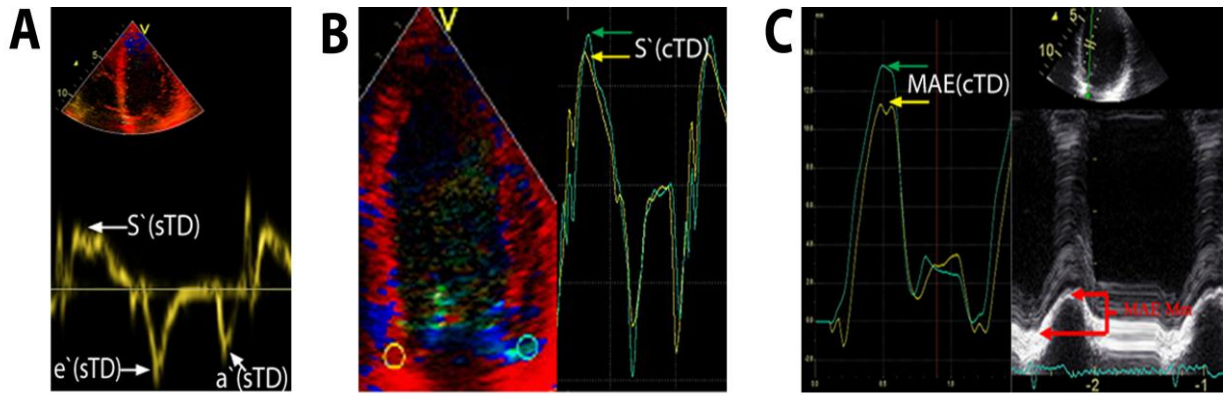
A: Spectral tissue Doppler (sTD) derived septal mitral annulus velocities. Peak systolic velocity $S'(sTD)$, early diastolic velocity ($e'(sTD)$) and late diastolic velocity $a'(sTD)$ measured at the maximum of the Doppler spectrum with low gain setting. B: Velocity curves from colour tissue Doppler (cTD). Peak systolic mitral annulus velocity $S'(cTD)$ measured at the peaks. C: Measurements of systolic mitral annular excursion (MAE) by integrated velocity curves from colour tissue Doppler MAE(cTD) and by reconstructed M-mode MAE(Mm).
